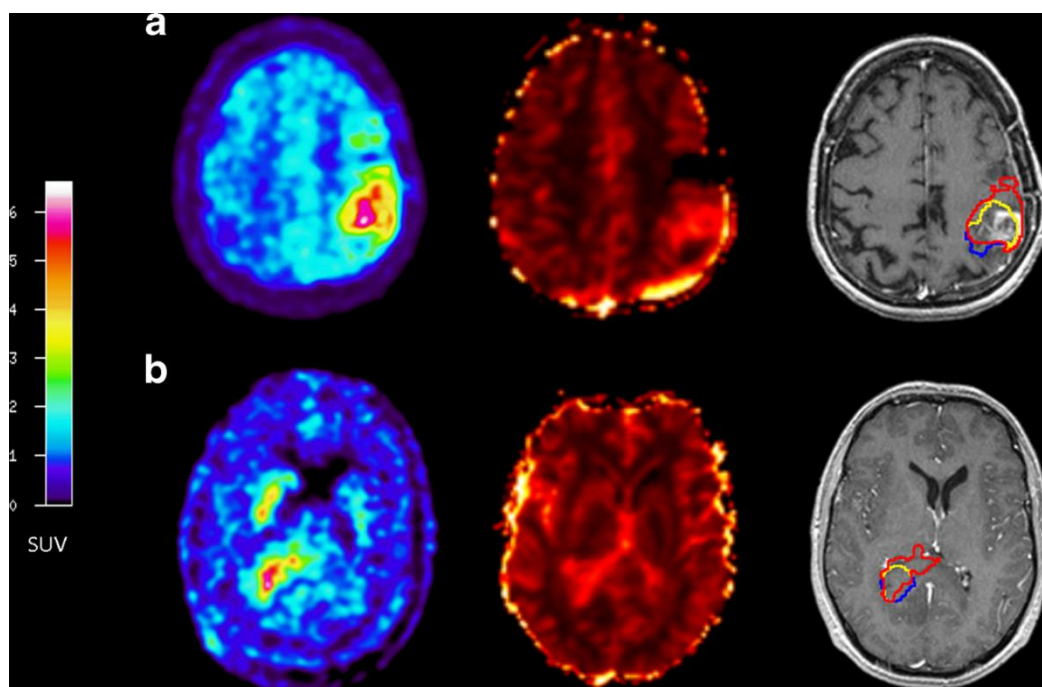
An example of spatial matching between tumor volumes from FDOPA-PET and rCBV images. These studies were selected from the studies with the highest volume overlap. From left to right: Contrast-enhanced T1-weighted image of axial FDOPA-PET, rCBV, and tumor VOI superposition (tumor volume from red FDOPA, tumor volume from blue rCBV, overlapping volume in yellow). a Patient 7, glioblastoma: FDOPA $_{vol 1.6}$ and rCBV $_{vol 1.6}$ are similar (25.55 ml and 26.30 ml, respectively). Spatial joint 31.8%. b Patient 34, uncontrast gliomatosis cerebo: FDOPA $_{vol 1.6}$ and rCBV $_{vol 1.6}$ are 19.12 ml and 7.17 ml, respectively; Spatial joint 12.49%.
